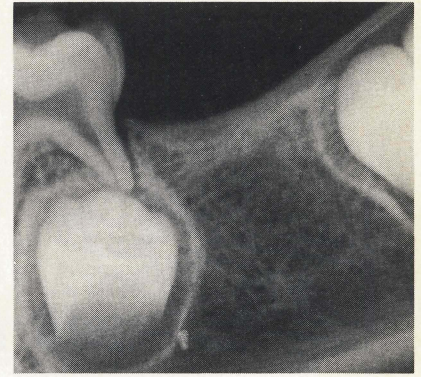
Osseous remodeling demonstrated in periapical radiograph taken nine months post-surgery.
